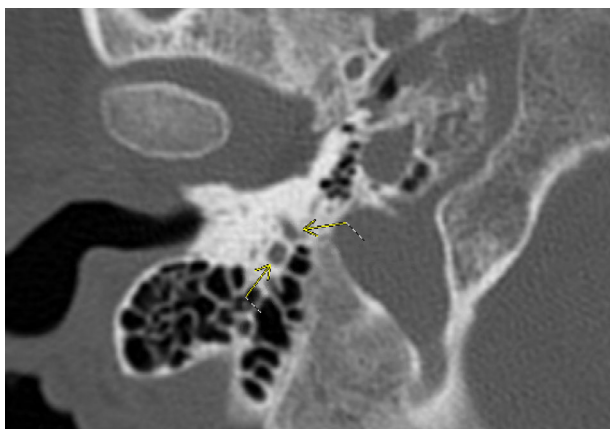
Axial computed tomography temporal bones showing bifurcation of vertical segment of the right facial nerve through two separate bony canals.
